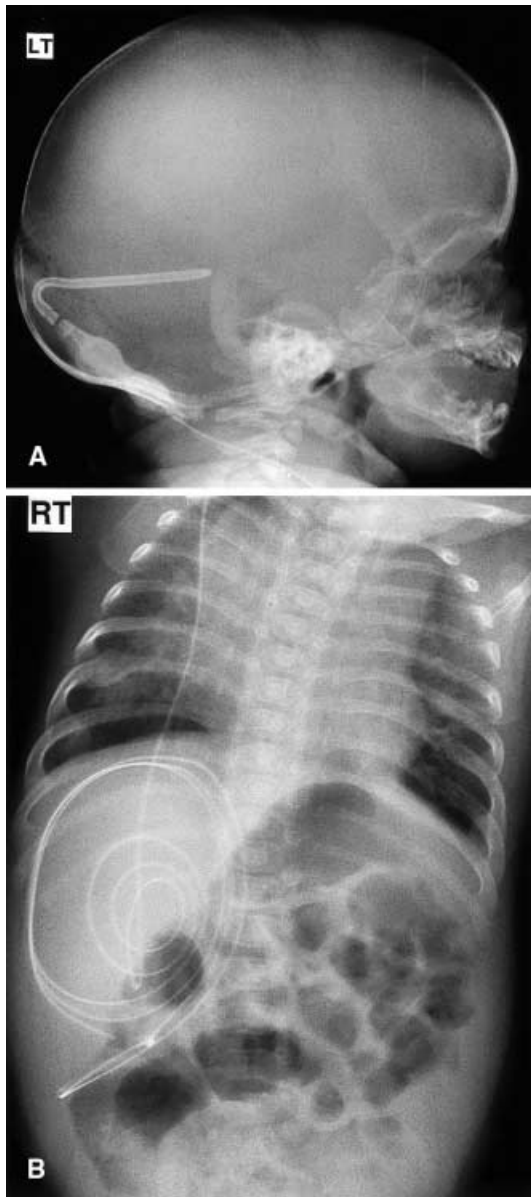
A Plain skull X-ray demonstrating the intraventricular position of the catheter. B Thoraco-abdominal plain X-ray showing intra-peritoneal position of the distal catheter. Note early coiling in the peritoneum
